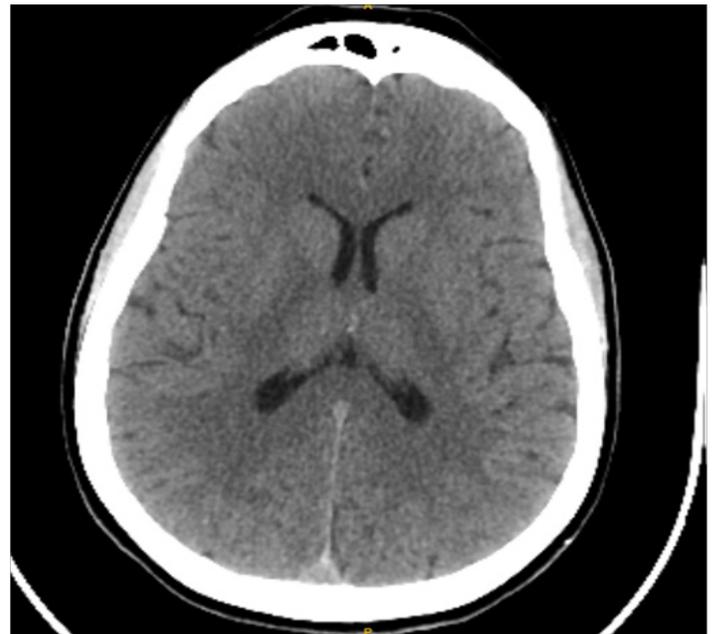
Brain CT performed because of cephalaea.
